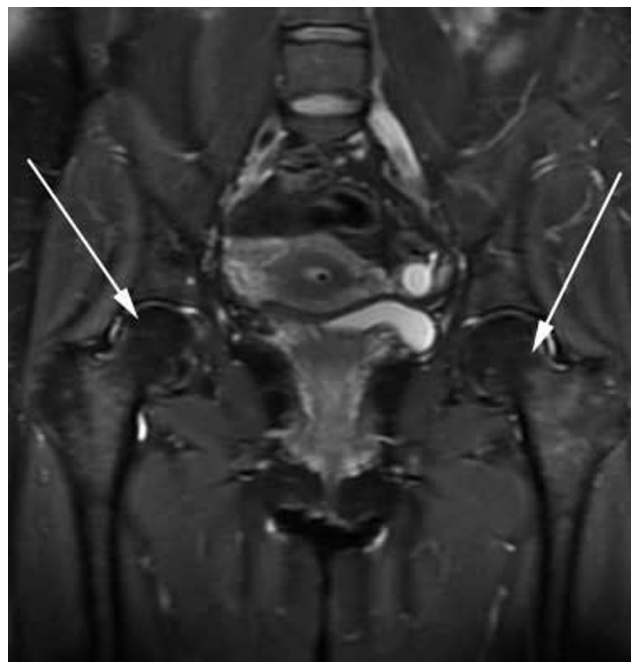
34-year-old female with osteoporosis of pregnancy. Resolution of abnormal increased signal as seen on prior MRI, coronal STIR image.
